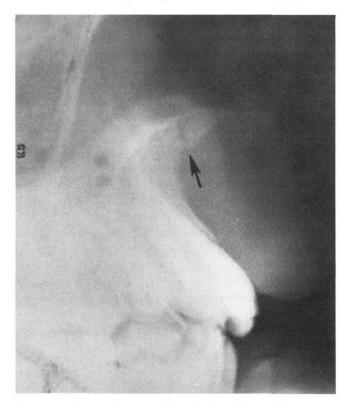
A lateral extraoral occlusal radiographic view of the maxilla showing a non-displaced fracture of the anterior nasal spine.
